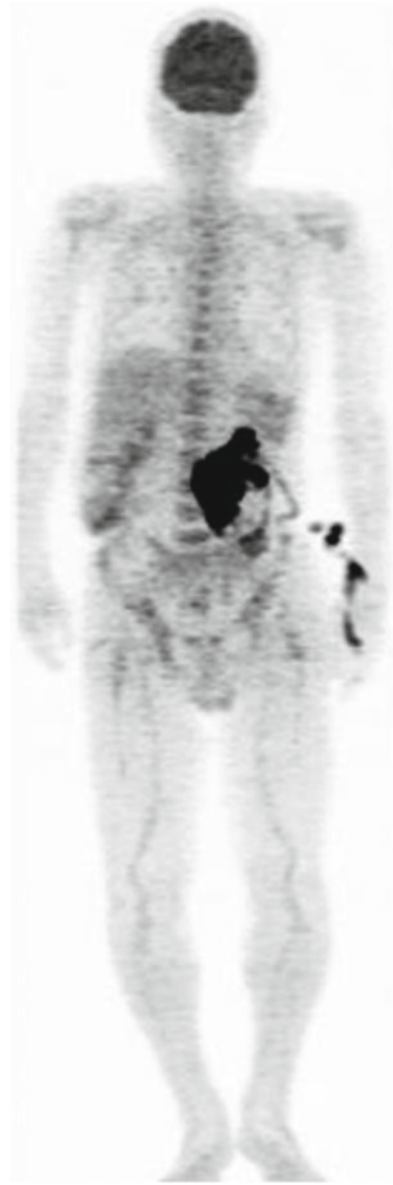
Anterior MIP image of a patient with retroperitoneal tumor (*small arrow*). Note increased uptake in nephrostomy tube (*large arrow*). Subcutaneous extravasation and superficial contamination of FDG solution are seen in left forearm (*arrowhead*)
